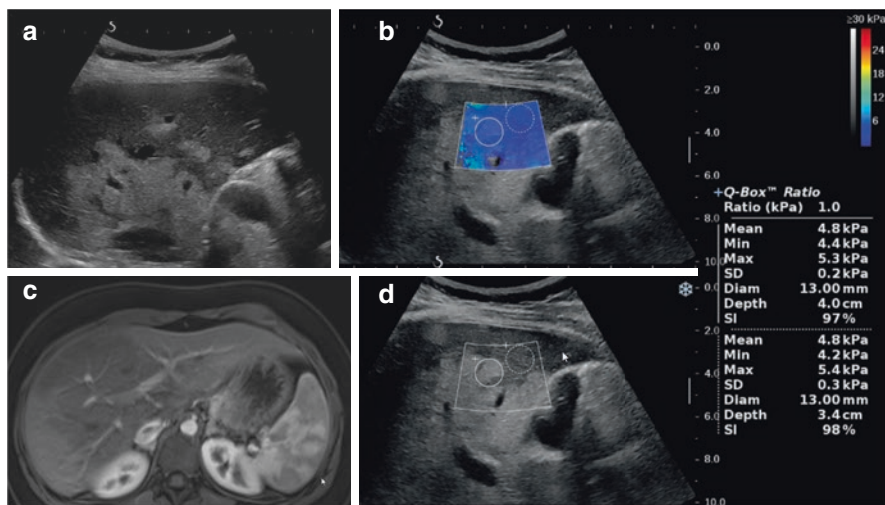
Atypical aspects of steatosis on ultrasound. Panel (a): very large focal fatty changes (FFC) (arrow) in a young, asymptomatic female patient. Notice the geographic margins and the lack of compression of the intrahepatic vessels. Panels (b and d): 2D-SWE was used within the hyperechoic area and in the normal liver parenchyma, and showed identical results, suggesting FFC. Panel (c): Magnetic resonance excluded solid lesions and confirmed the diagnosis of large FFC
